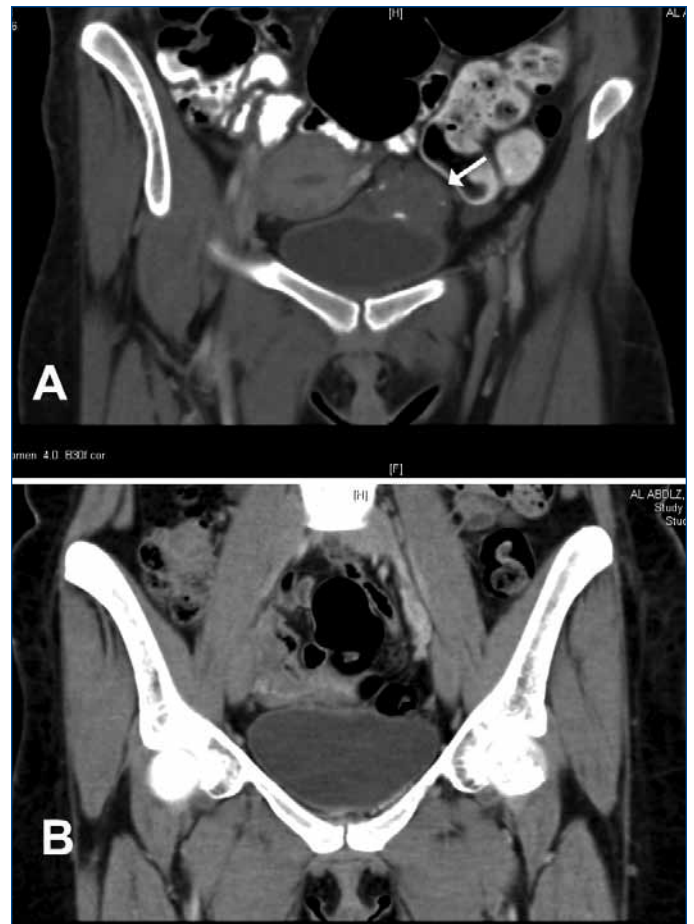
Coronal section of a computed tomography scan of the abdomen showing A: bladder tumour (arrow) and B: normal bladder 6 months postoperatively.
